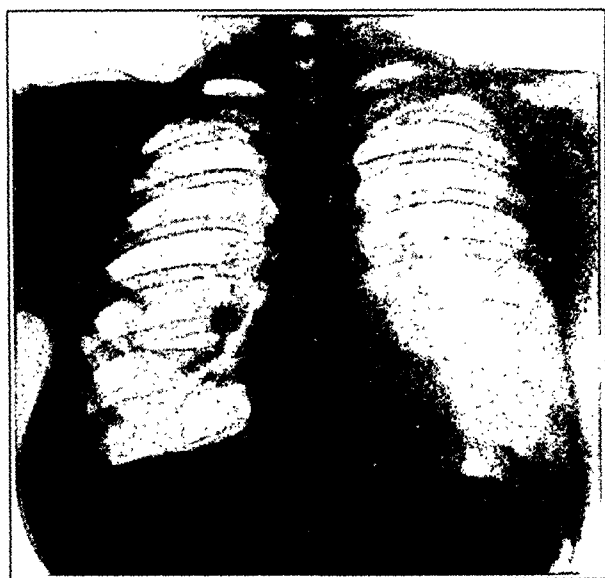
(female, aged 26).—Roentgenogram showing an early tuberculous cavity in the midfield of the right lung close to the area of the root, with a collection of fluid resembling a nontuberculous abscess; there were no other pulmonary findings. Note the crossing of the cavity by the interlobar fissure, as in figure 6. Further study revealed that the cavity was located in the apex of the lower lobe.
